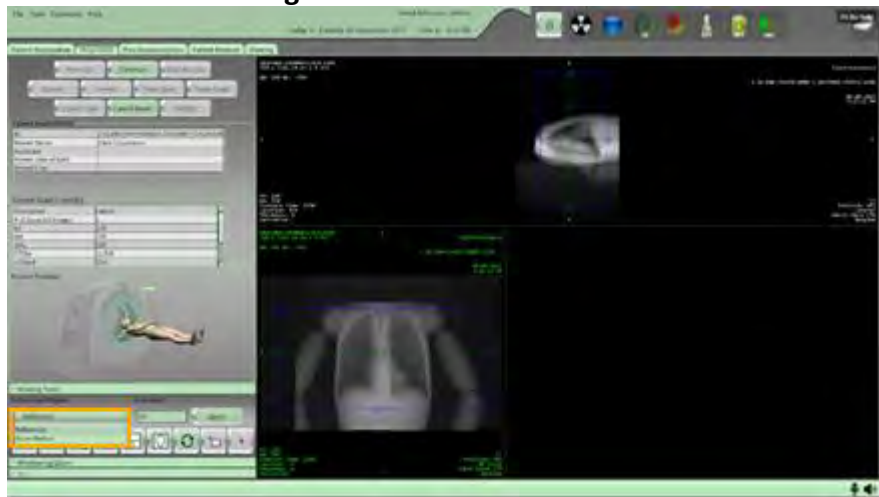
Active Scan Region – Bolus Reference or Helical CTA
